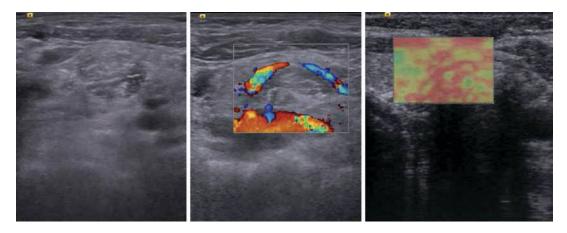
A 38-year-old woman with breast CA. USG image showing metastatic lymph node in the neck. Ultrasound image shows loss of degeneration of hilum
